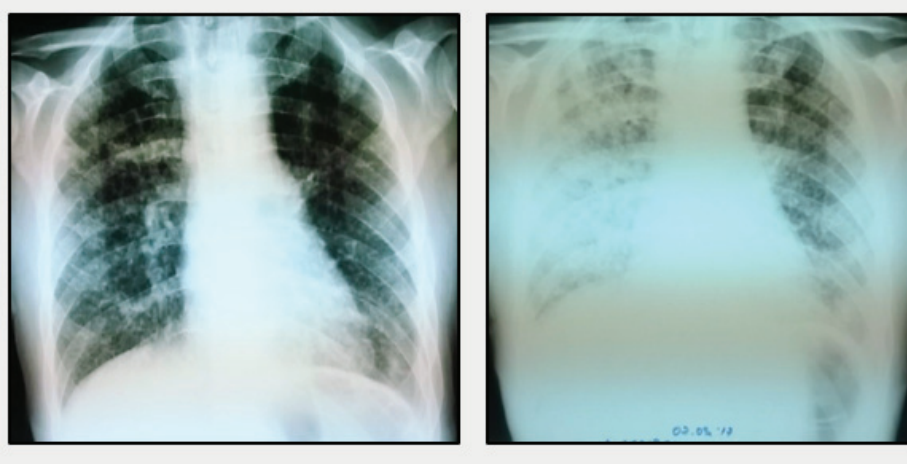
A) Chest x-ray on admission showing bilateral reticulo-nodular shadows, predominantly right; B) Chest x-ray at the 6th day of hospitalization showing bilateral infiltrates (an acute respiratory distress syndrome – ARDS).
